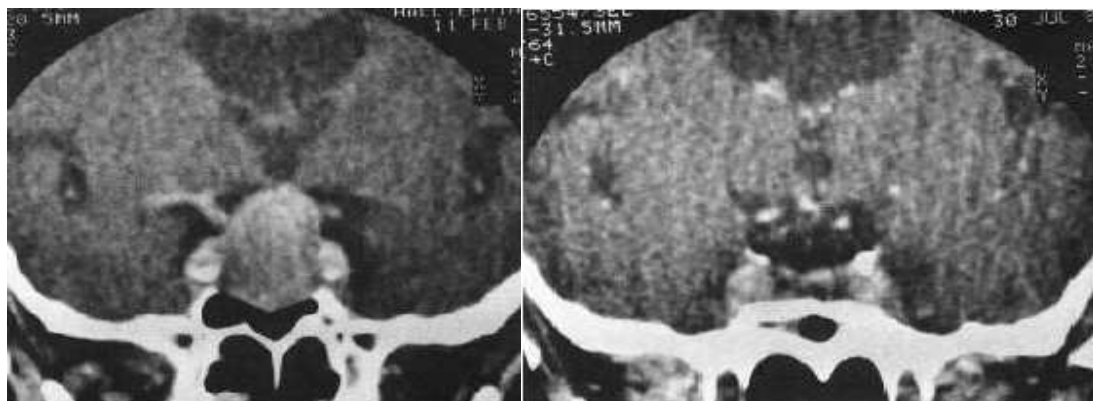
Brain CT scan (coronal sections) of pituitary adenoma showing suprasellar extension (Pre- operative Lt. and post operative Rt.)
